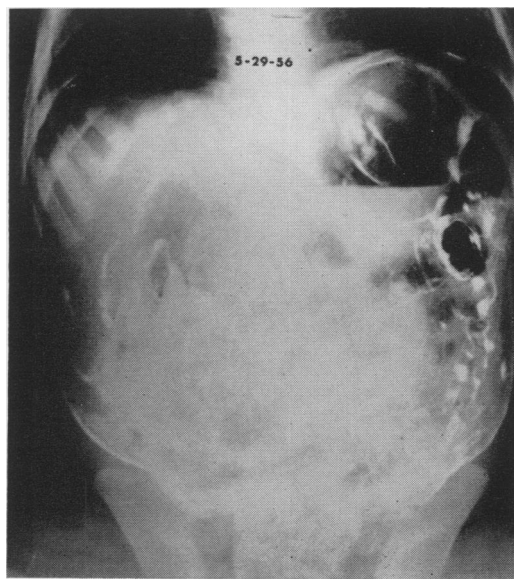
Preoperative abdominal x-ray, case #2.
